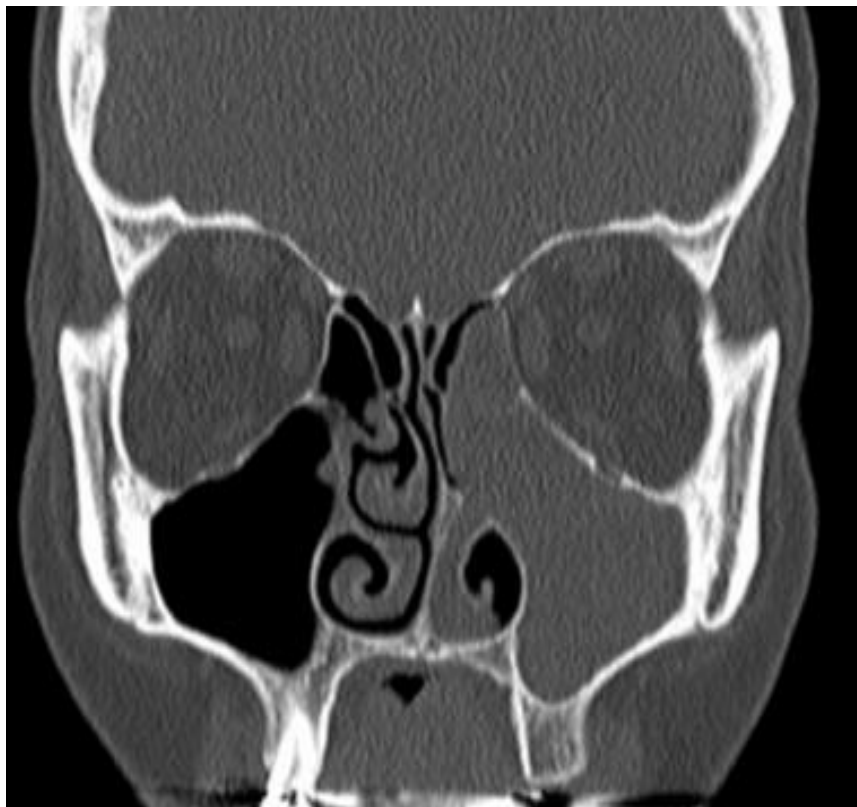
CT PNS coronal section showing left Antrochoanal Polyp
